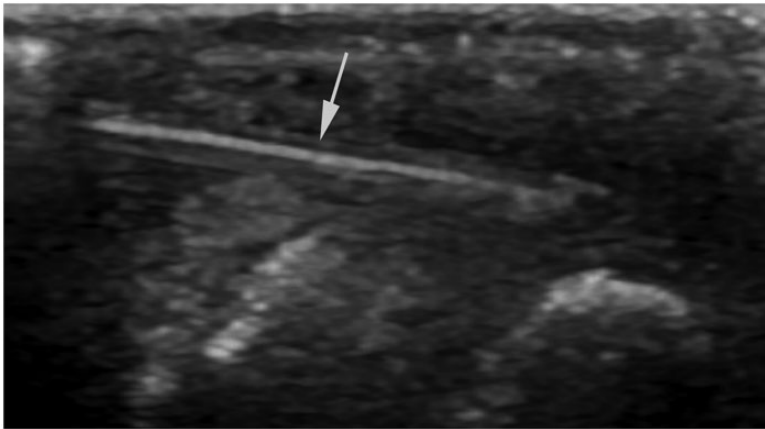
Ultrasound-guided synovial biopsy of a knee joint. The needle is clearly visible (arrow).
